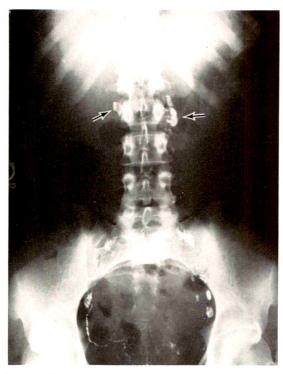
The 24 hour roentgenogram of the abdomen demonstrates opacification of the upper paraaortic lymph nodes which are presumed to have filled from the principal (lumbar) pedicles of the corpus uteri.
